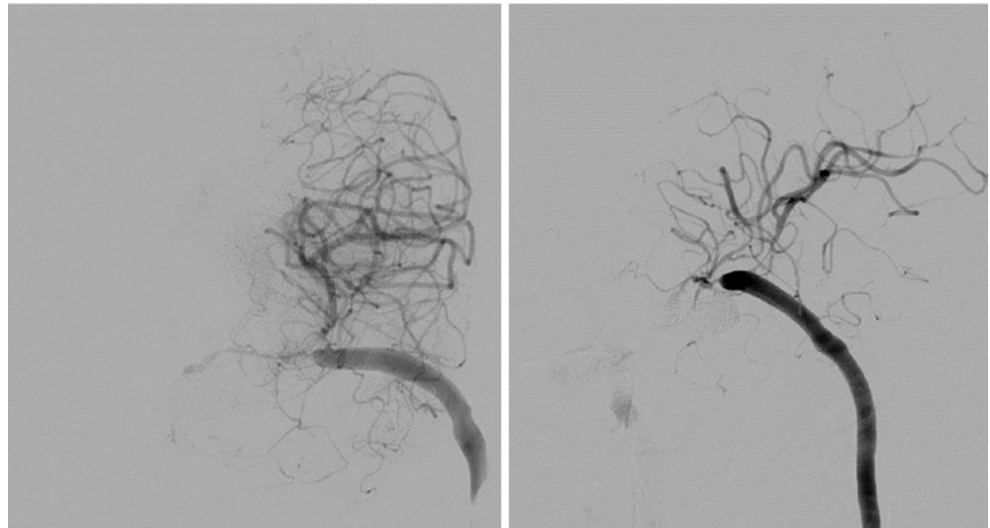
(a) Brain CT scan demonstrating the presence of subarachnoid hemorrhage mainly localized within the left Sylvian fissure. (b) Angio-CT scan documents the presence of a left ICA aneurysm extended from the supraclinoidal segment to the ICA bifurcation. (c) Cerebral angiography and embolization of the aneurysm
